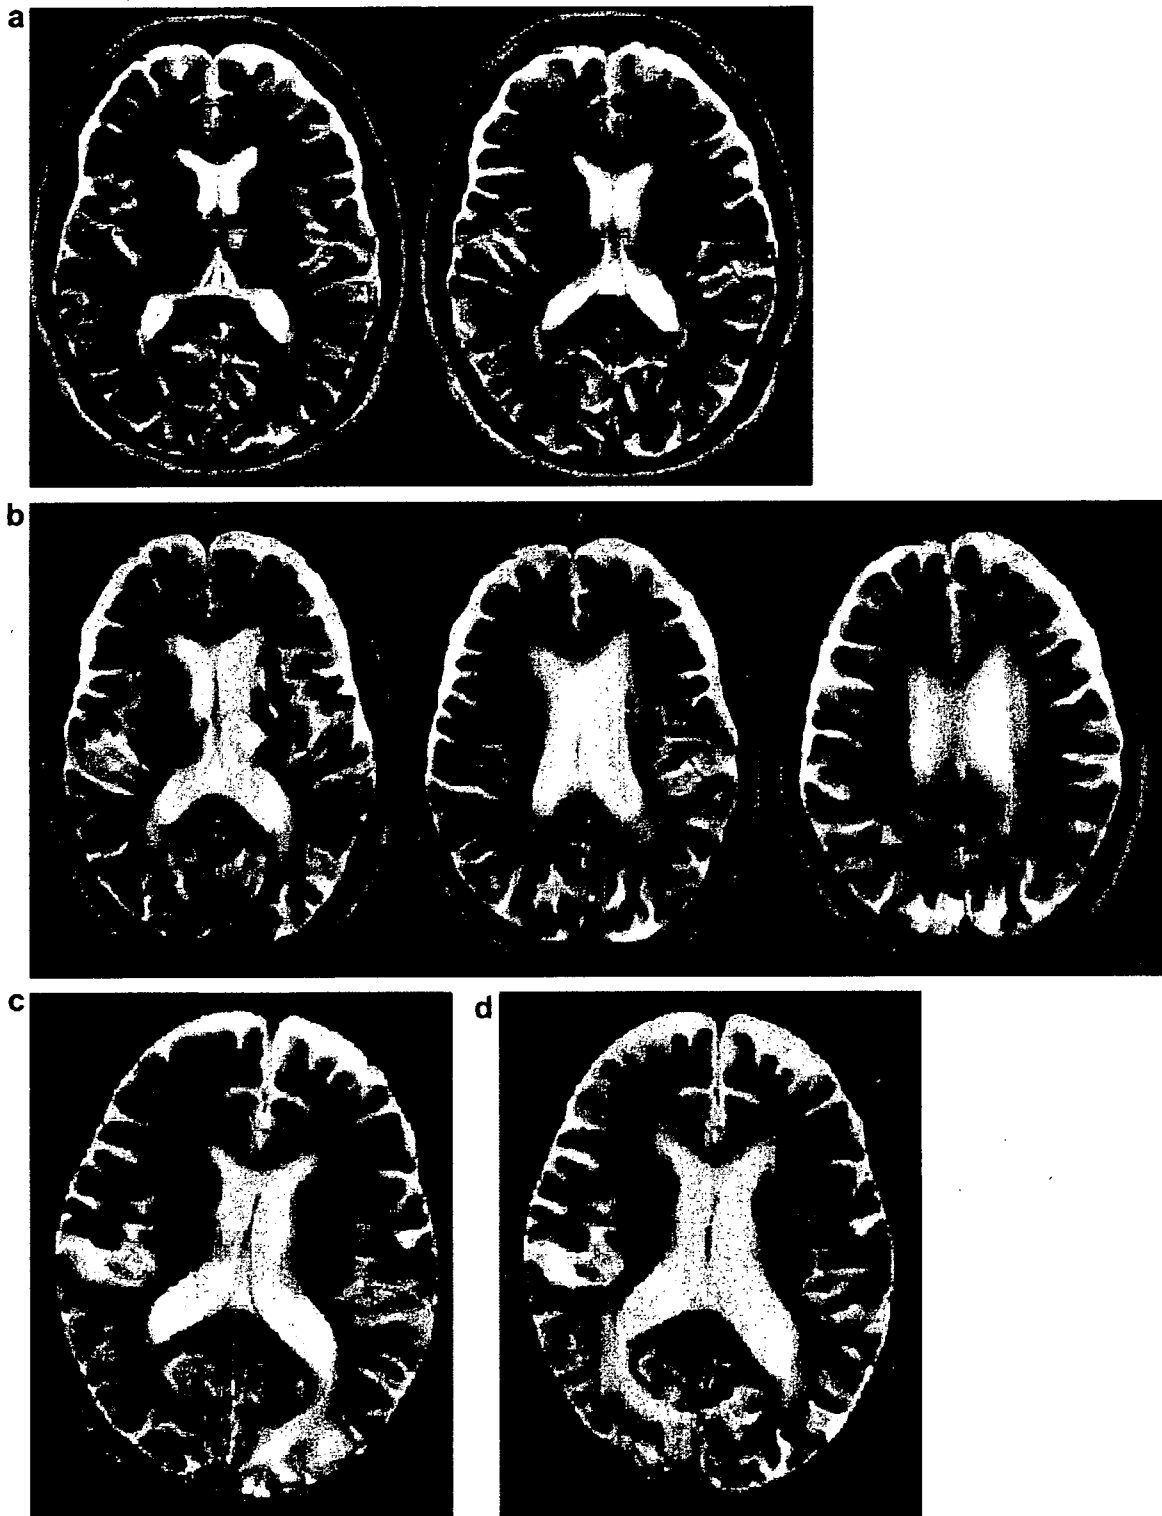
(a) Pretreatment T₂-weighted magnetic resonance imaging (MRI) study of Patient 1, who then underwent whole brain radiotherapy (WBRT) plus stereotactic radiosurgery (SRS). (b) T₂-weighted MRI scan of Patient 1 at 46.6 months after initial brain treatment. (c) Pretreatment T₂-weighted MRI study of Patient 2, who then underwent WBRT plus SRS. (d) T₂-weighted MRI scan of Patient 2 at 15 months after initial brain treatment.
